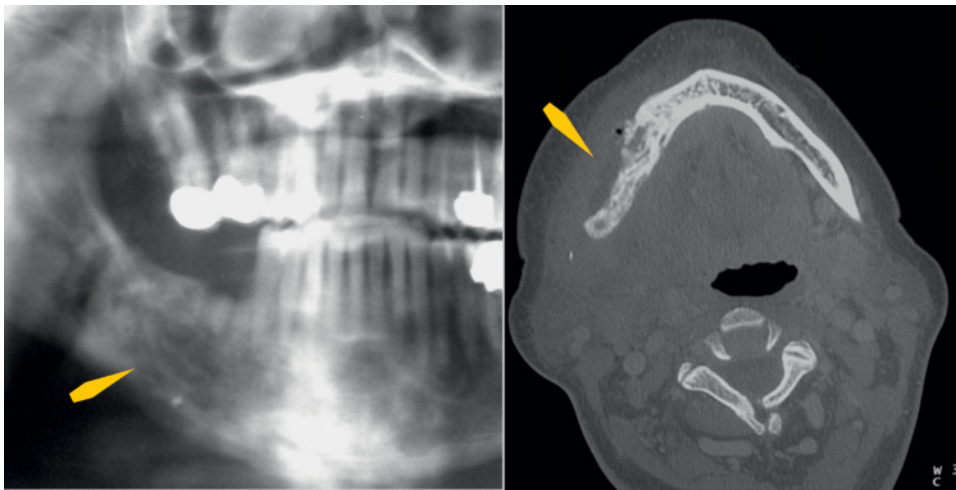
Comparison of pantographic radiograph (left) and computed tomography (right) images of chronic nonsuppurative osteomyelitis of the posterior right mandible, on the facial surface (arrows). Note the great destruction of the cortex overlying the area of involvement. The irregular, moth-eaten destruction hinted at on the radiograph is much more obvious on the scan.
